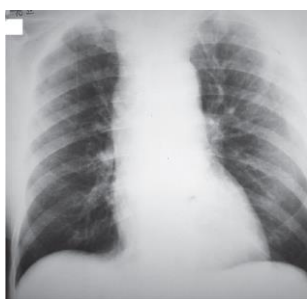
X-ray of the chest and subphrenic space of patient M. (22.10.19). No focal and infiltrative shadows were found. Unaltered pulmonary pattern. The roots of the lungs are not dilated, the sinuses are free. No signs of pneumoperitoneum
